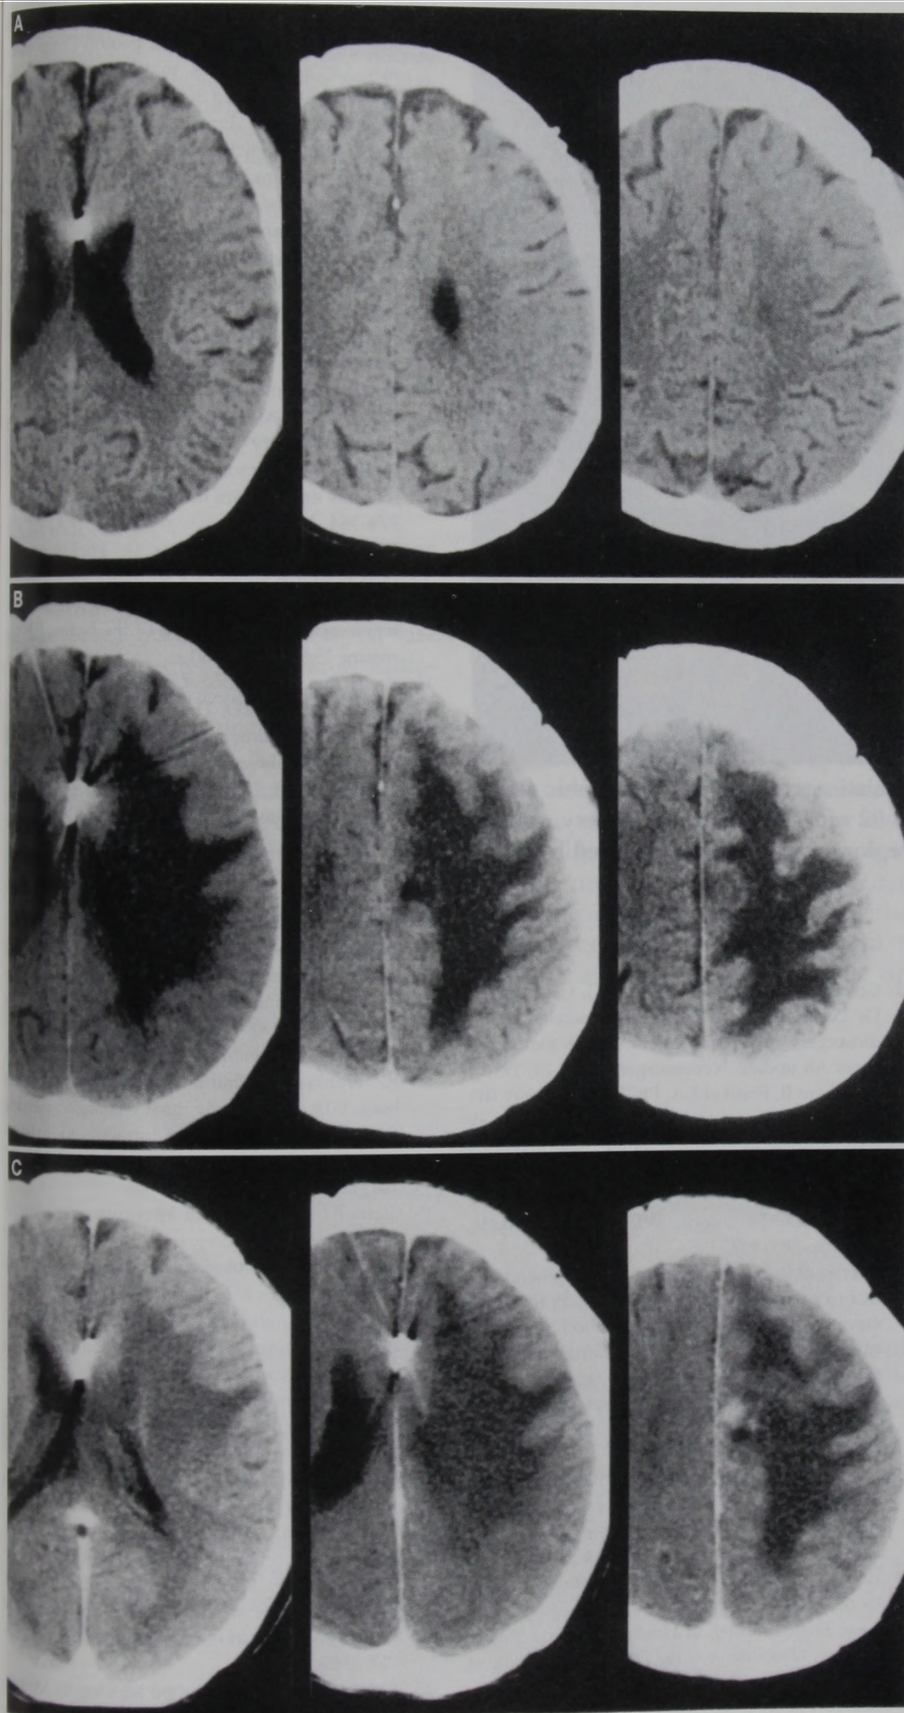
Sequential computed tomographic scans obtained 38 (A), 91 (B), and 92 (C) months after radiosurgery; with (C) and without (A and B) contrast enhancement.
